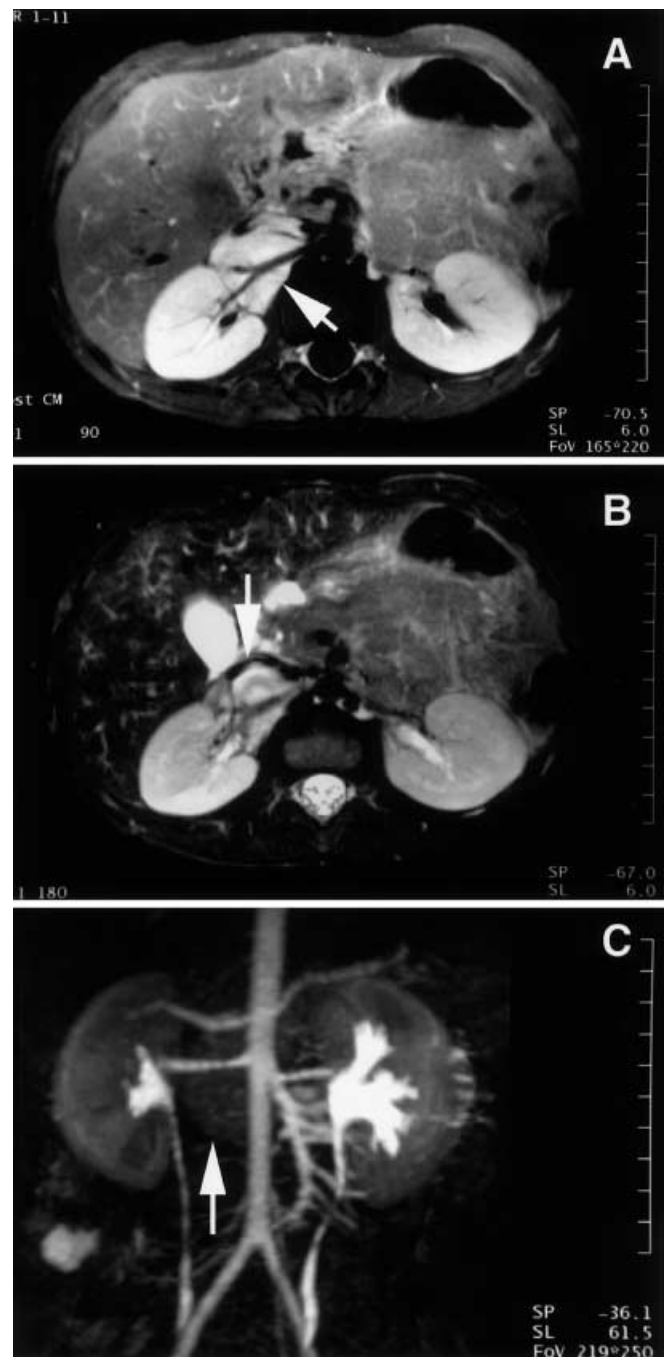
Magnetic resonance imaging of the abdomen shows a right perinephric mass. A Axial view of mass (margin denoted by arrow) encasing right renal artery. B Axial view of mass depicting marked anterior displacement of right renal vein (arrow). C Magnetic resonance angiography of the abdomen in the coronal view showing a single right renal artery coursing through the mass (arrow). Hypoattenuation of lower pole of right kidney is consistent with ischemia or infarct
